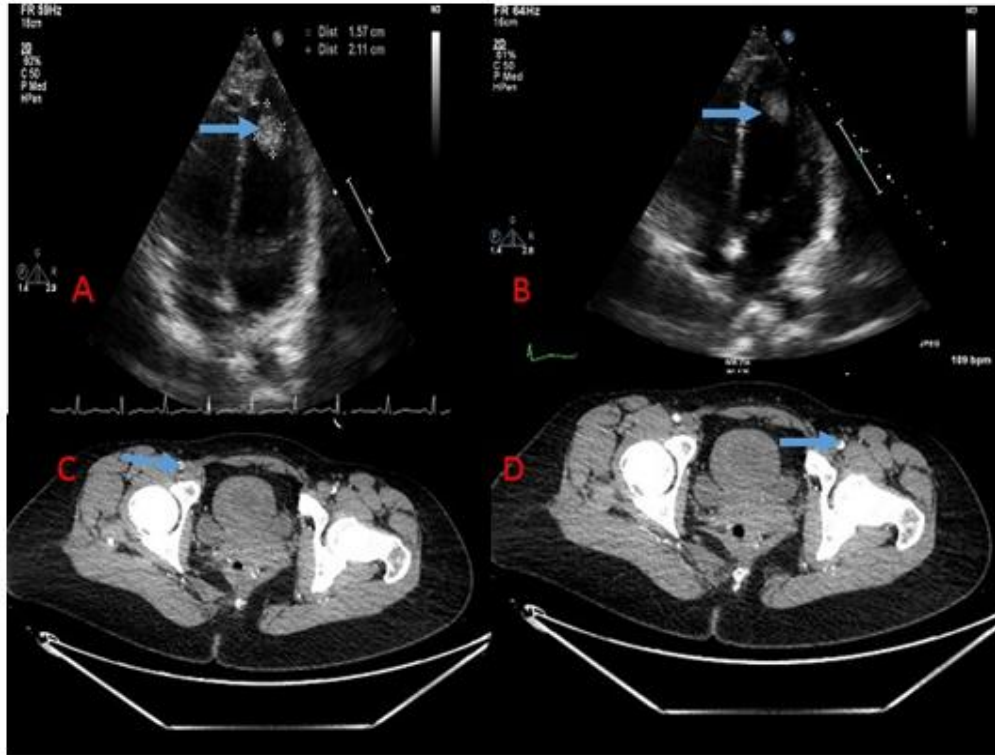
A-B Echocardiogram showed left ventricle Thrombus (Blue arrows). C-D CT angiogram showed peripheral arterial embolus (Blue Arrows)
